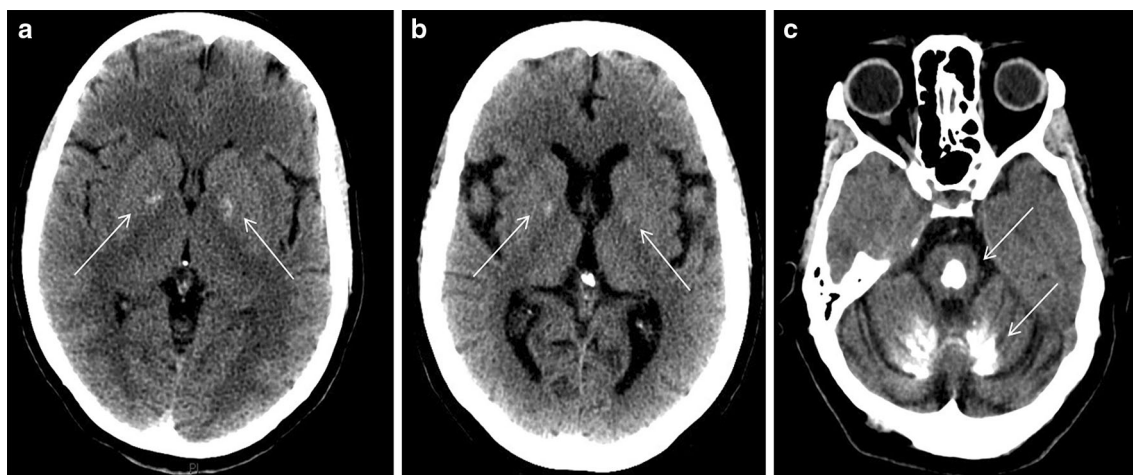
Brain calcifications detected at CT scans of different patients. *Arrows* indicate calcifications in basal ganglia (a, b), brainstem and cerebellum (c)
